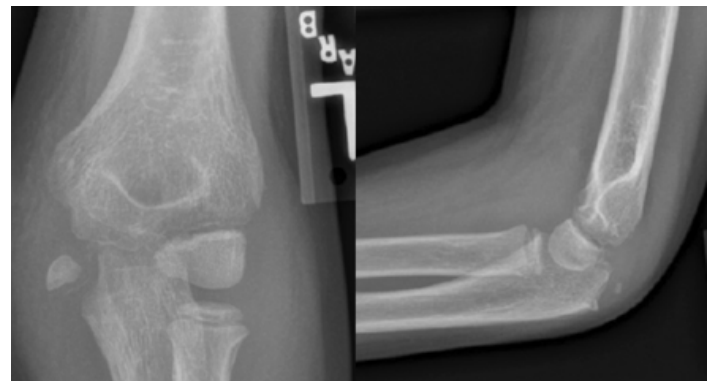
Initial presentation x-rays showing significantly displaced fragment.
